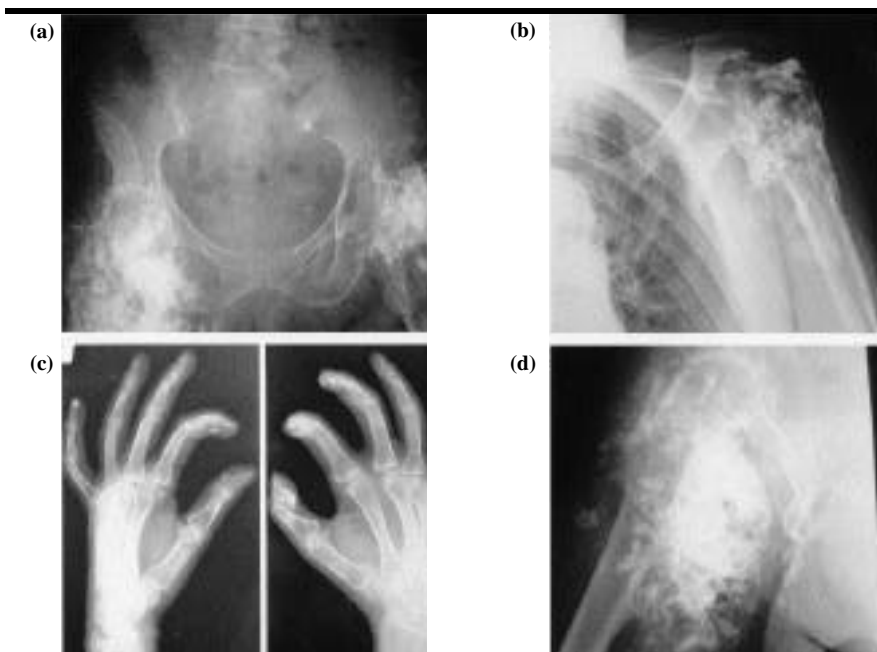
X-ray images of ectopic calcifications at different levels: pelvis (a); left shoulder (b); hands (c); and right hip and thigh (d).
